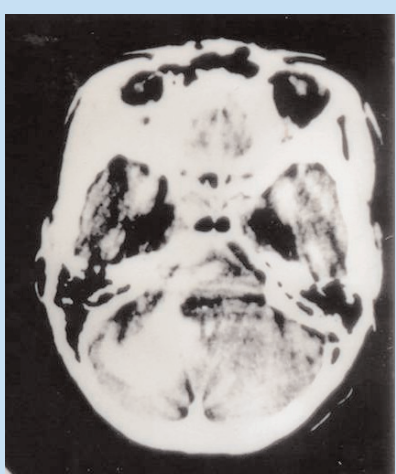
CT scan of the brain (non-contrast) demonstrating a large right-sided cerebellar haemorrhage with extension into the adjacent brainstem and subarachnoid space.
